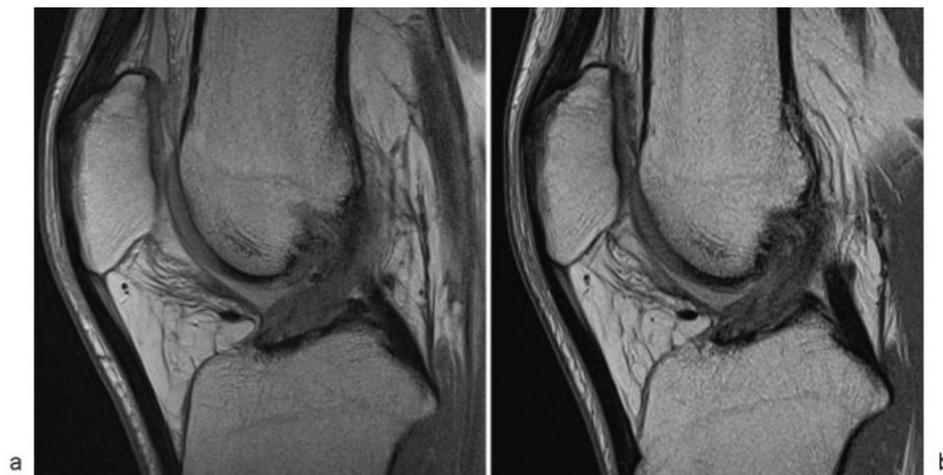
Internal bracing of the anterior cruciate ligament (ACL). (a) Postoperative sagittal proton-density-weighted image at 5 months. (b) Follow-up MRI at 12 months showing decrease of the signal intensity of the ACL repair tissue, indicating tissue maturation.
